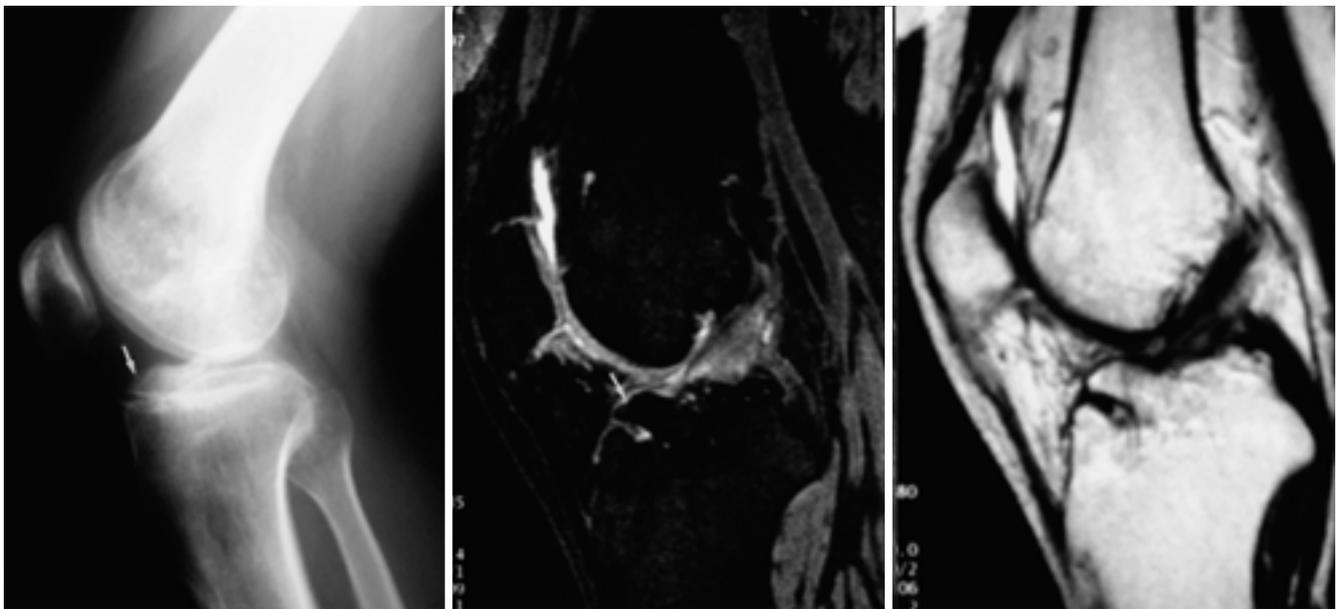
Case 2. A 25-year-old man with type II avulsion fracture of the tibial spine and partial ACL tear. A, B. Plain radiograph and sagittal DESS image show anterior elevation of the fractured fragment (white arrow). C. Sagittal FSE proton image shows increased signal intensity within the ACL. A type II avulsion fracture with partial tear of the ACL was identified at arthroscopy.
